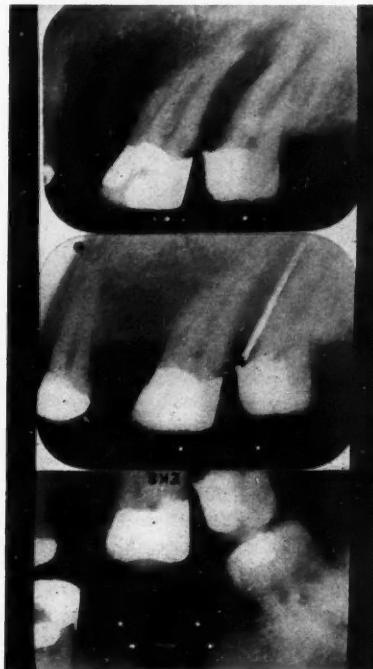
These three radiographs show the necessity for careful clinical examination where superimposition of palatal bone may prevent the diagnosis of bone loss from the routine radiograph.
